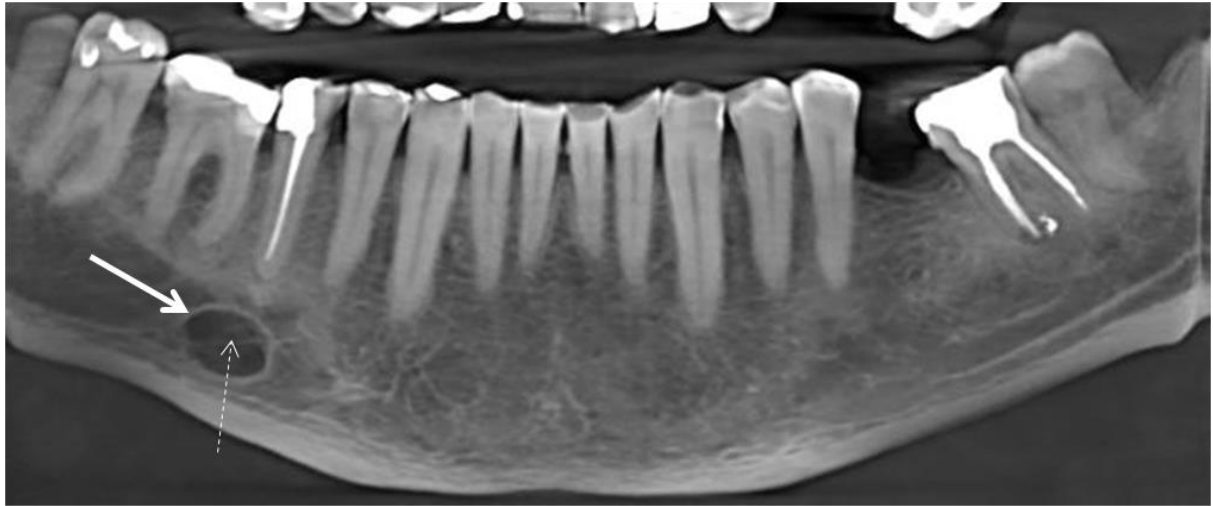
3D CBCT reconstruction of a unilocular posterior SBC shown in figure 6 (cropped image).
